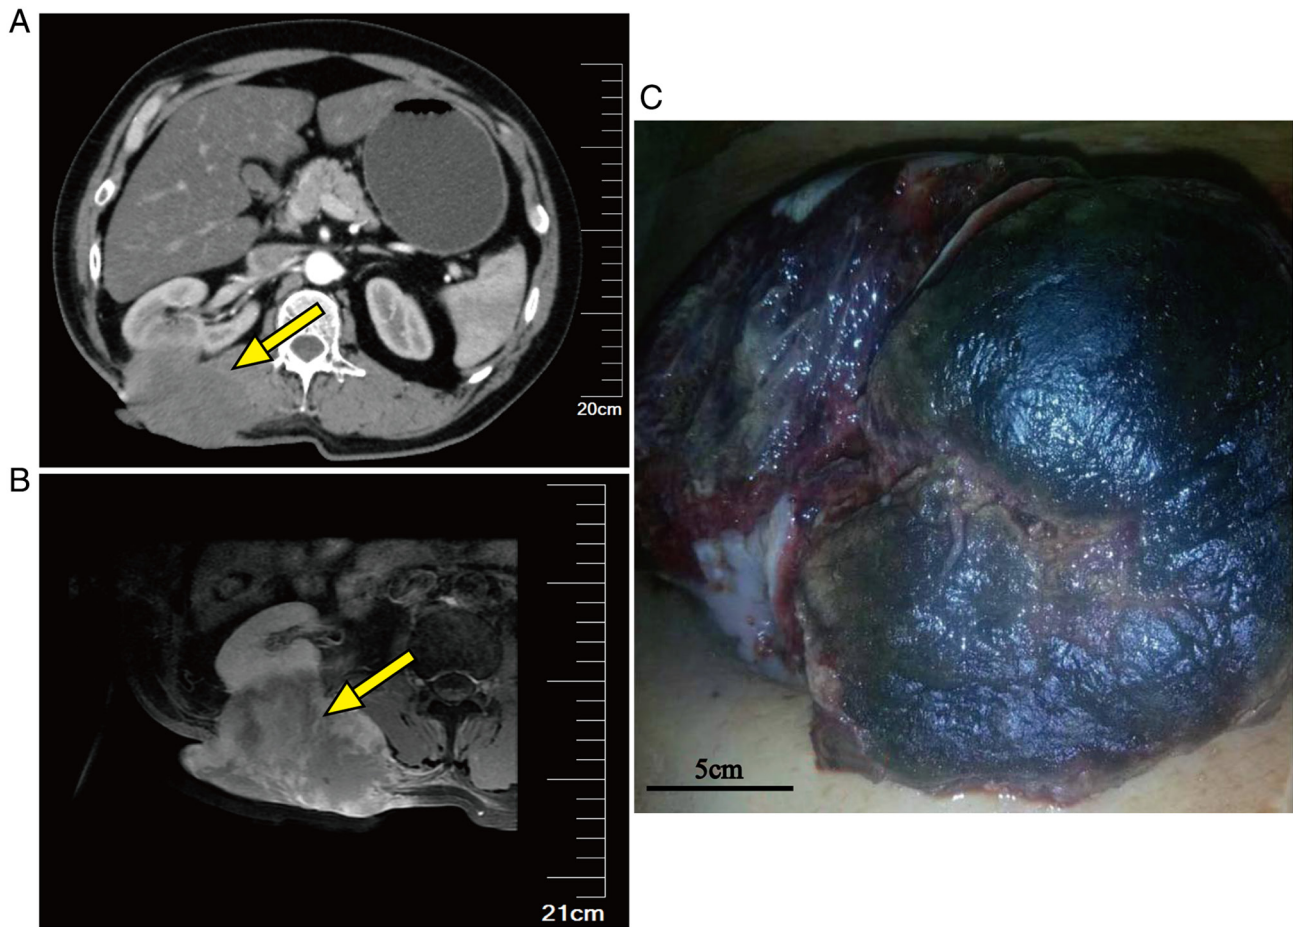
Imaging examination 8 months after the third operation. (A) Computed tomography examination; (B) Magnetic resonance imaging examination; and (C) Clinical image of the visible lesion.
